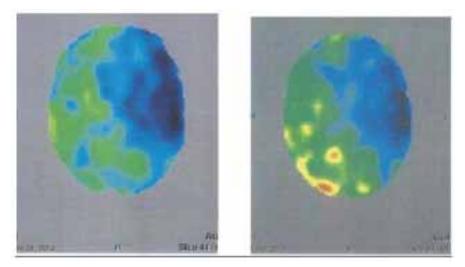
Pre and Post PET CT scans showing improvement after stem cell therapy in stroke
